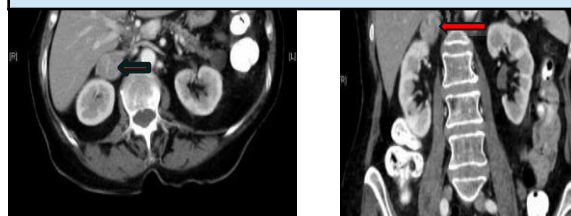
CT scan of the abdomen without intravenous contrast revealing a right adrenal mass, left transverse view and right coronal view
